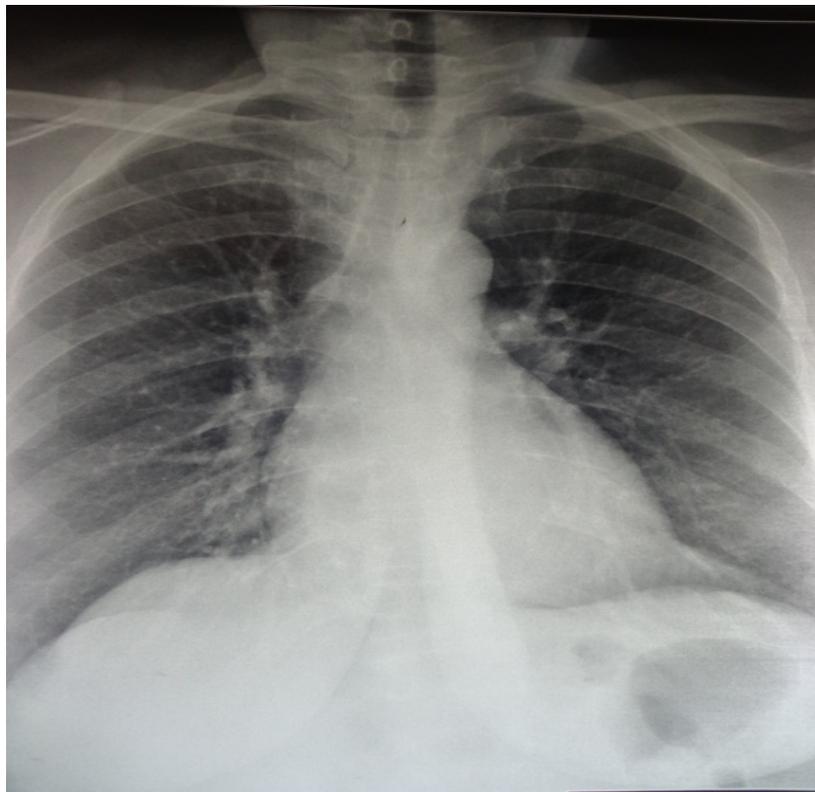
Normal chest X-ray
